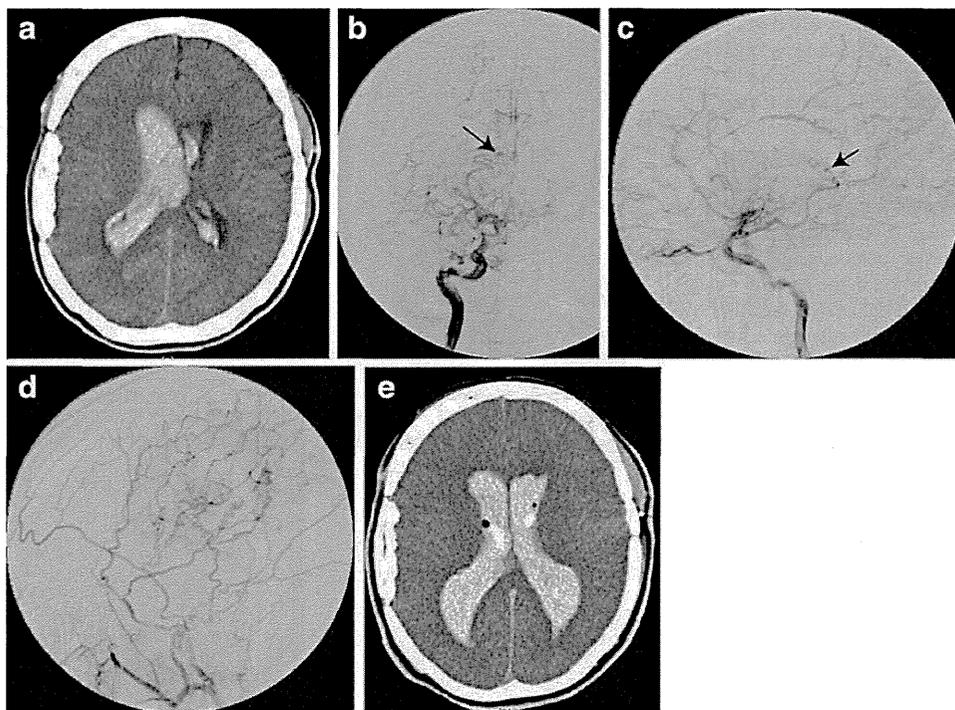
Case 4. a Computed tomography at first hemorrhage; b–d angiography after the first hemorrhage; anteroposterior (b) and lateral (c) views of the internal carotid angiography after first hemorrhage revealing occlusion of the internal carotid artery and dilated posterior choroidal artery accompanied with microaneurysms (*arrows*); d external carotid angiography showing good patency of the bypass; e computed tomography at second hemorrhage demonstrating massive intraventricular hemorrhage, resulting in fatal outcome
